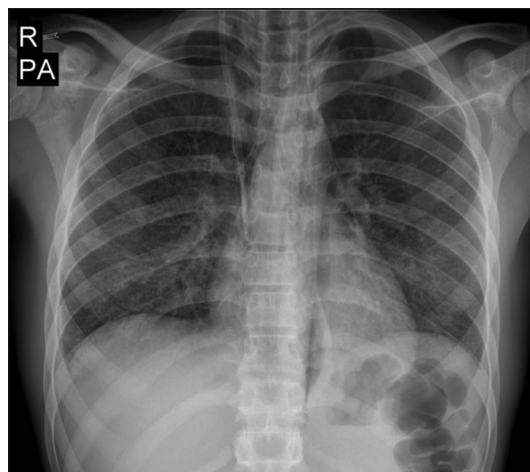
First chest X-ray
